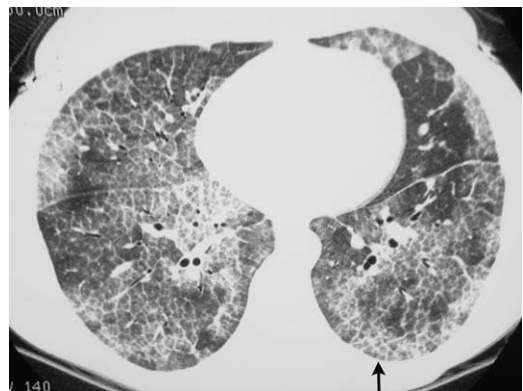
PAP. HRCT image shows typical ground-glass opacity with superimposed “crazy-paving” pattern (*arrow*). Crazy-paving is the meshwork of lines that represent reversible intralobular and interlobular interstitial thickening by edema and cells.
